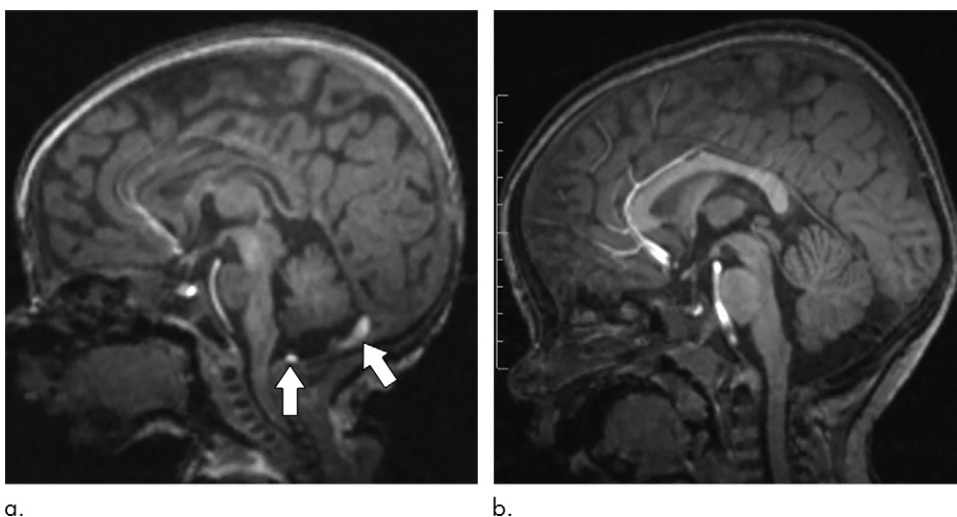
(a) Sagittal T1-weighted magnetization-prepared rapid gradient-echo MRI scan in a 14-day-old neonate shows small amounts of hyperintense subdural hematoma in the posterior fossa (arrows). (b) Follow-up sagittal T1-weighted magnetization-prepared rapid gradient-echo MRI scan at 2 years is normal, showing no evidence of intercurrent hemorrhage.
